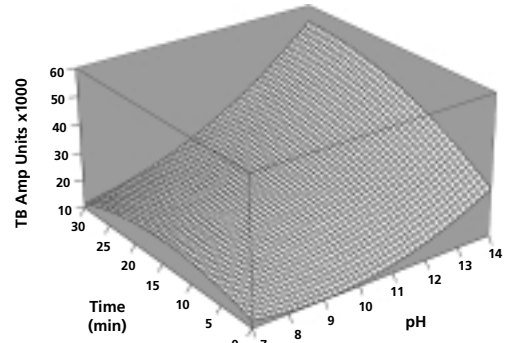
M.tb DNA Extraction by 65°C Heat, Alkali, and Ultrasonic Energy Exposure
